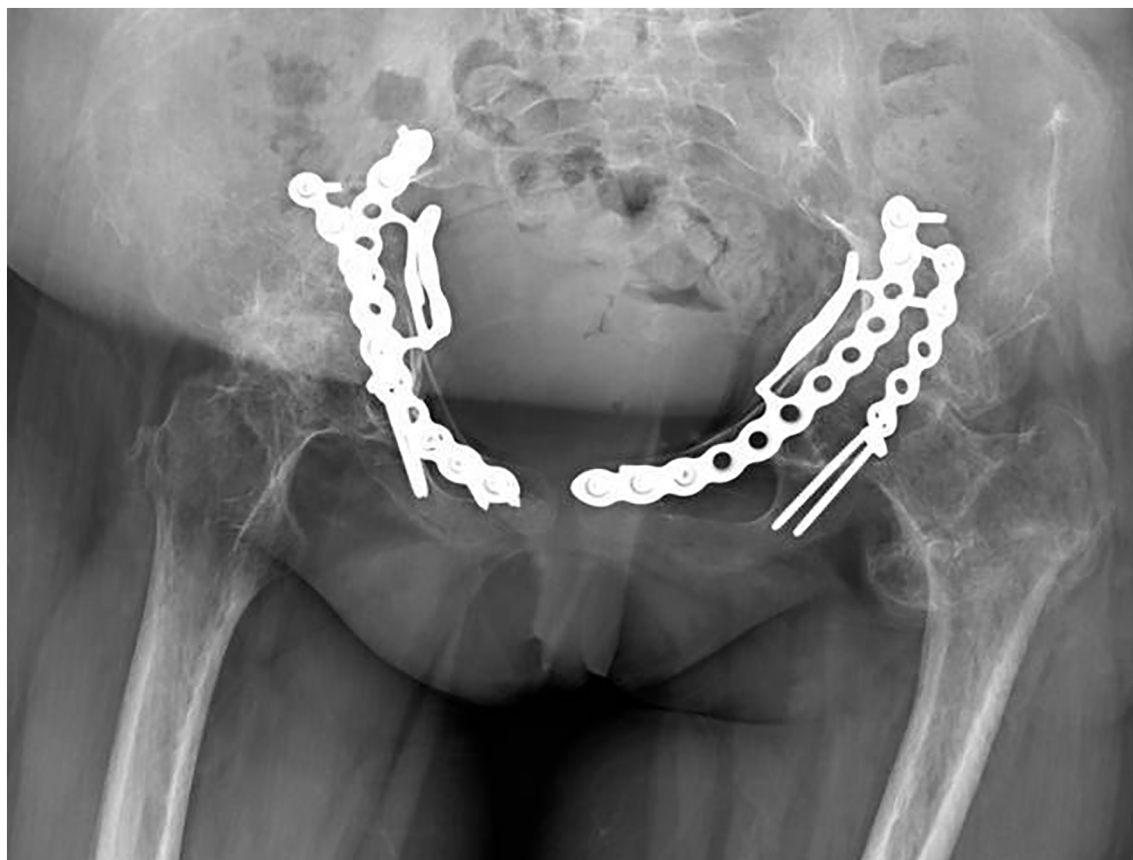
X-ray control at last follow-up as result of reconstruction of anterior column and quadrilateral lamina that show, despite bone fragility, a good fixation and a satisfactory bone stock to plan a future hip arthroplasty.
